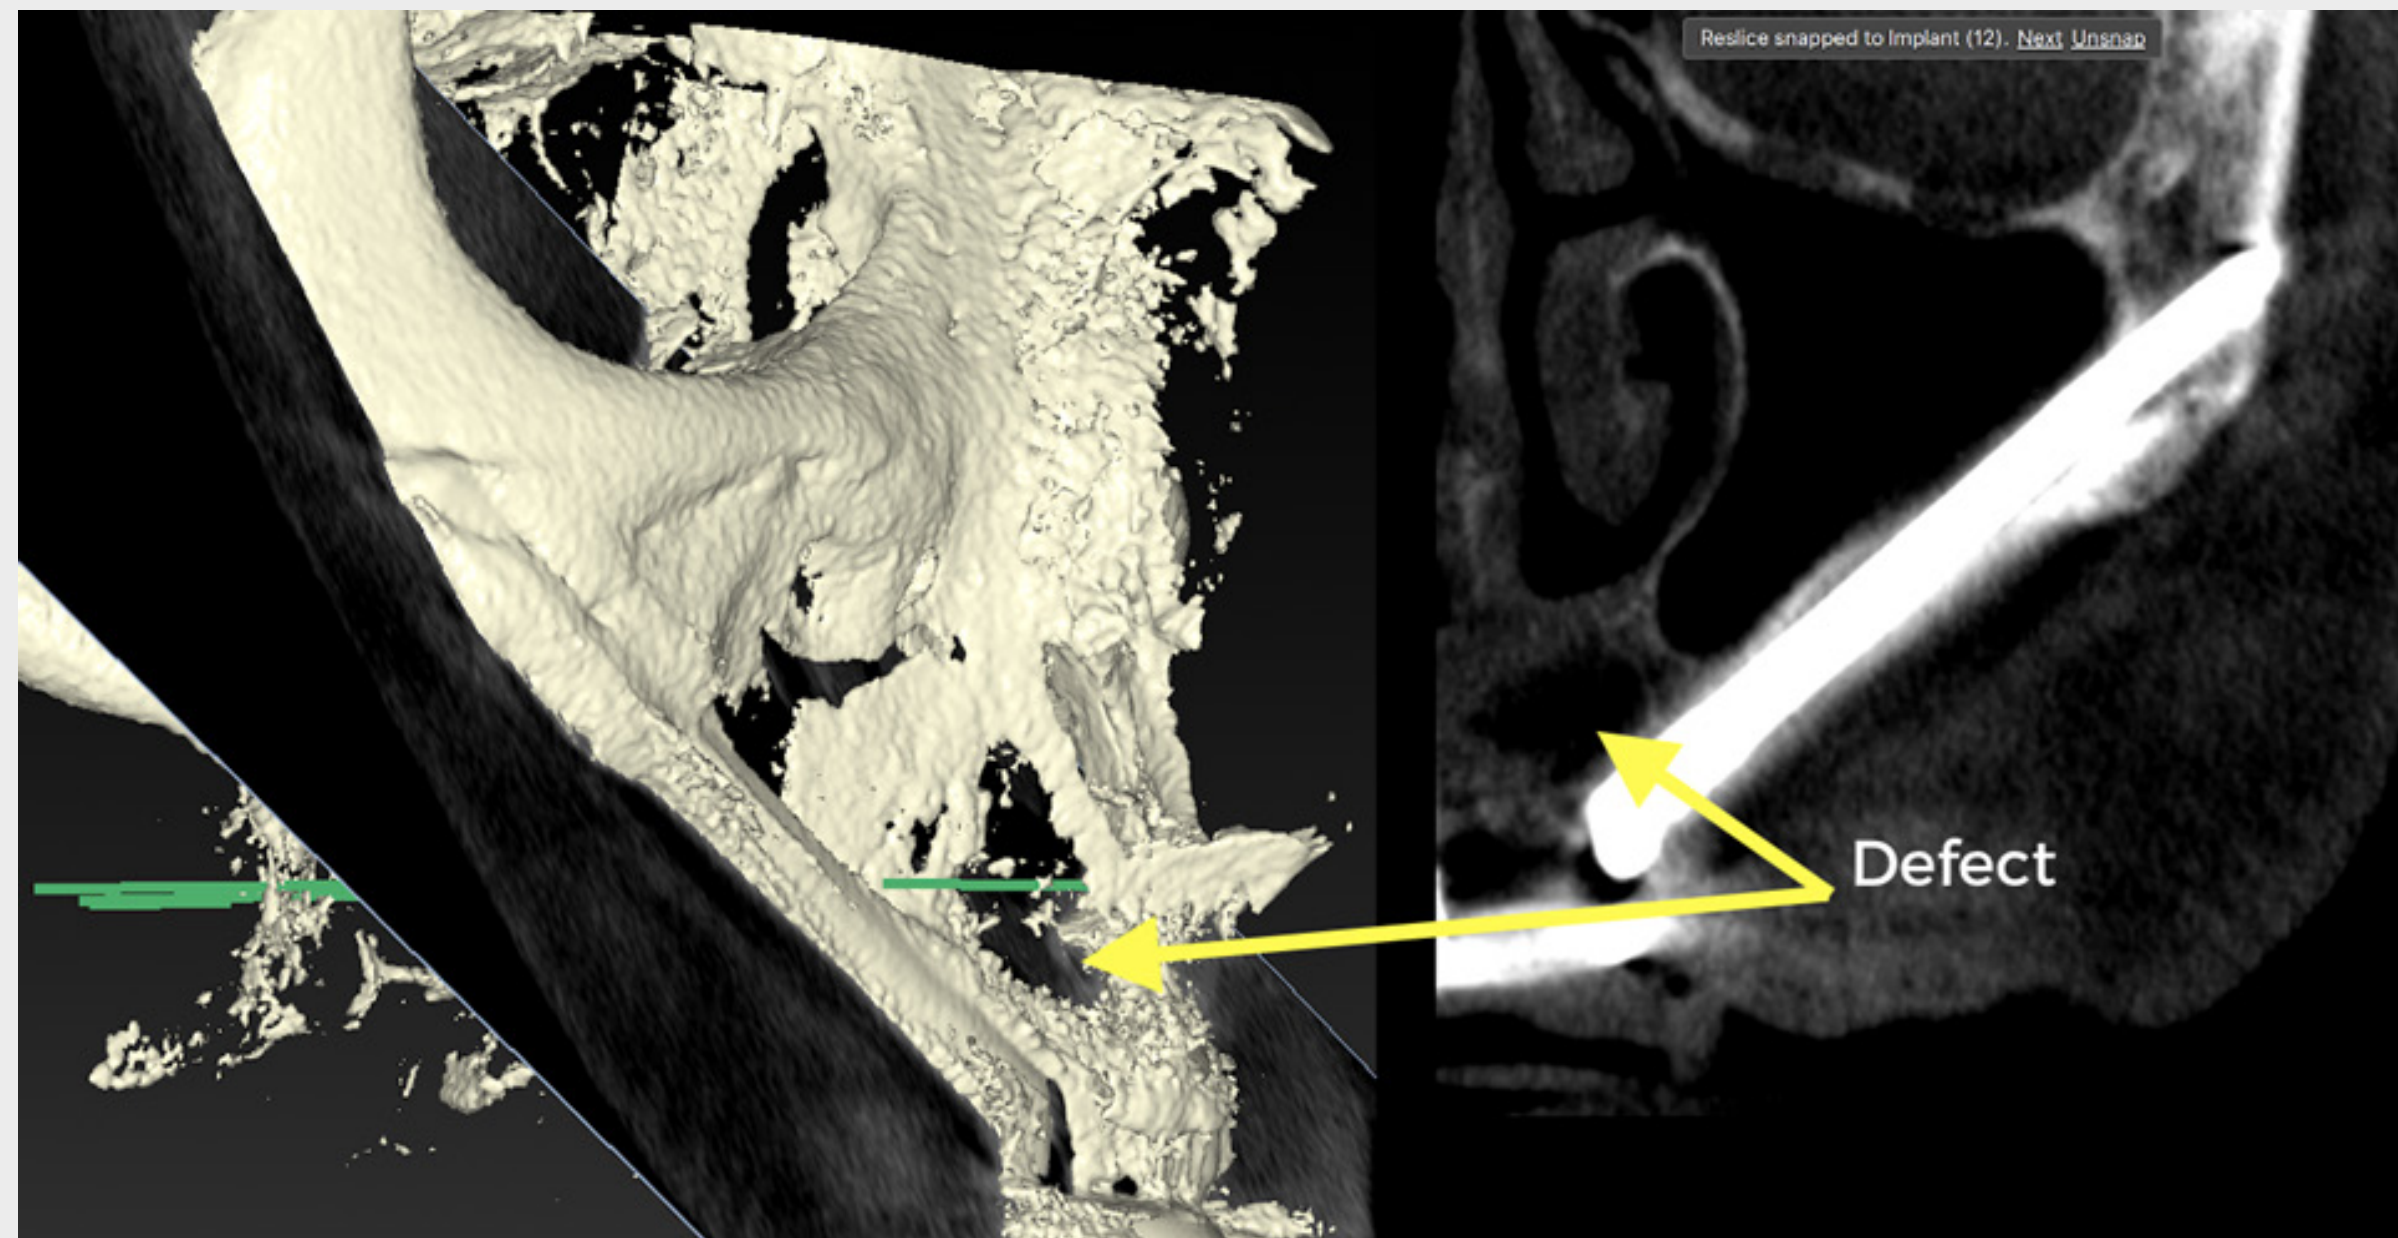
CBCT cut through the anterior right implant (ZAGA™ Type 2–3 - Straumann® Zygomatic implant, ZAGA™ Round,) showing the state of the maxillary sinus after one year. Compare with the pre-surgery status shown in figure 4a.
